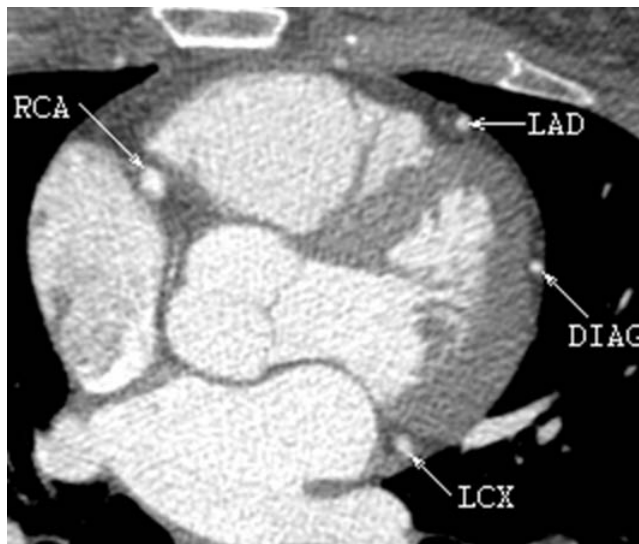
Axial slice of a CTA image shows contrast-enhanced lumen profiles of four major branches of the coronary artery: RCA - right coronary artery, LAD - left anterior descending artery, DIAG - its first diagonal branch, LCX - left circumflex artery.
